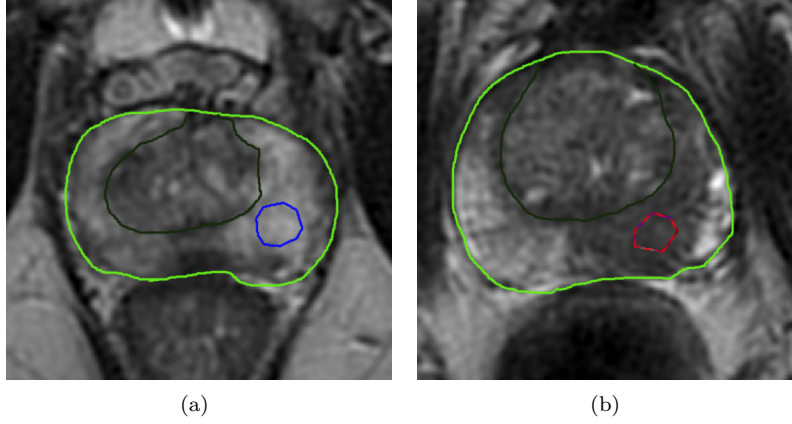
Two different 2D prostate T2-MRI slices where the prostate boundaries are marked in green, and the peripheral zones are marked in black. A normal ROI is marked in blue in (a), where an ROI is marked within a tumour in (b).
